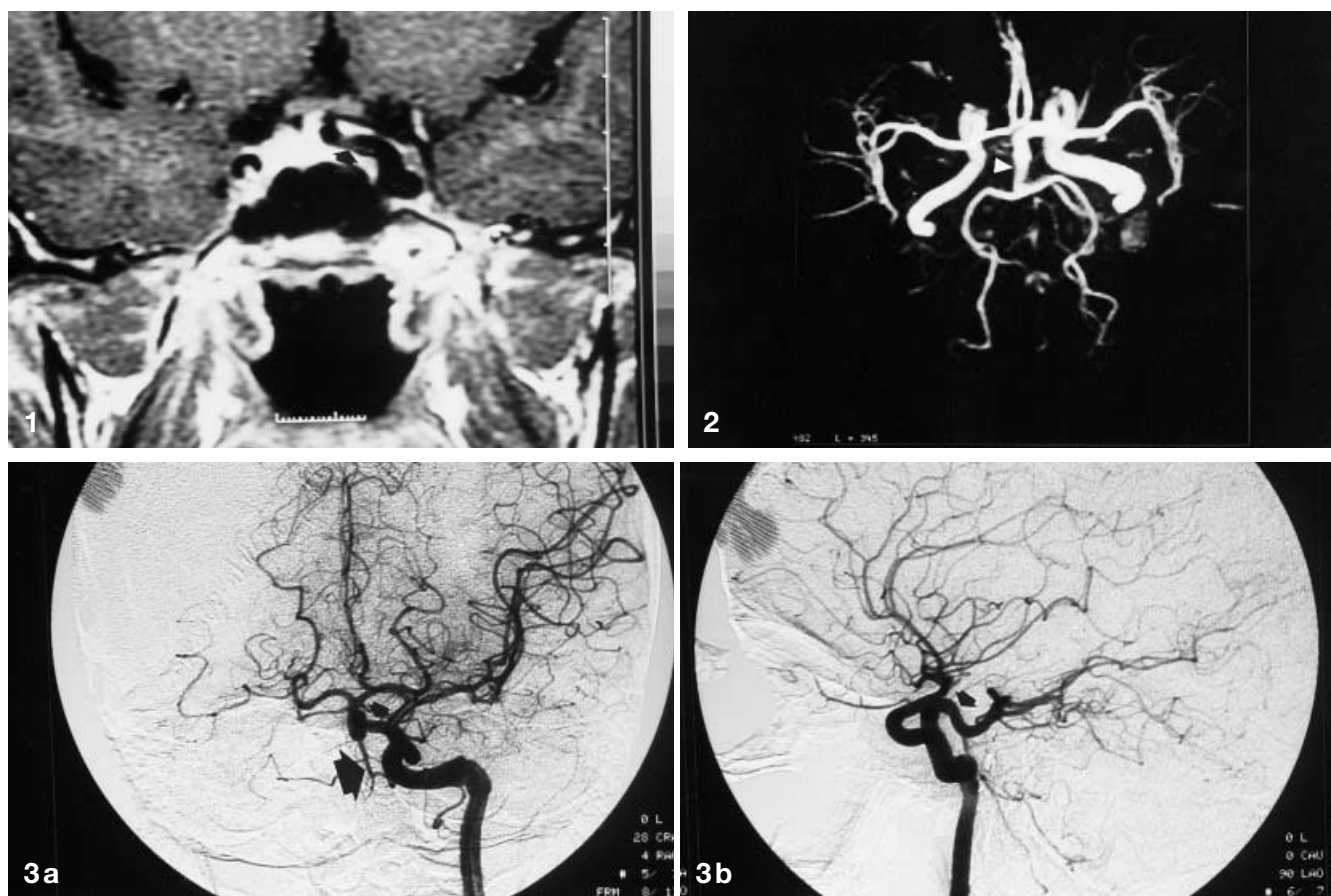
T1-weighted MR image in the coronal plane. Signal-void tubular structure arising from the cavernous segment of the left internal carotid artery compressing the left side of the pituitary gland and stalk (*arrow*). Left internal carotid artery is hyperplastic
